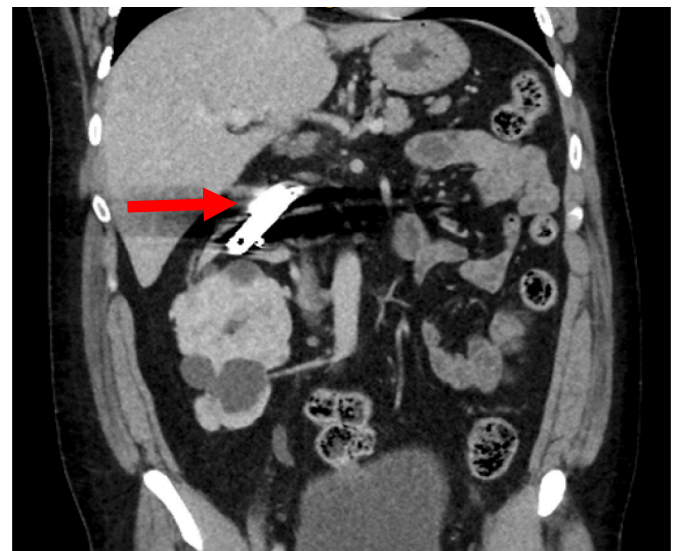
Day of ingestion CT abdomen/pelvis (CTAP) coronal slice: Nail clippers seen in D2/D3 of duodenum (red arrow).
